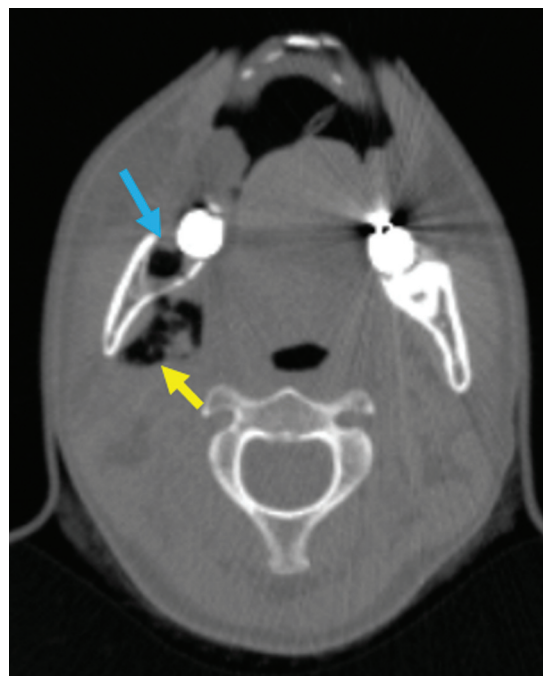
The blue arrow indicates the socket from which the third molar was extracted. The presence of air around the right parapharyngeal space in the mandible level (indicated by yellow arrows) was confirmed by computed tomography.
